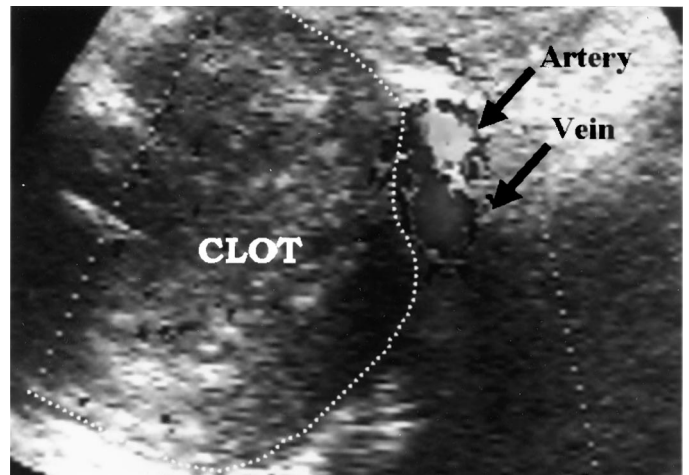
Color Doppler US image after injection of 5 mL (5000 U) of thrombin shows complete thrombosis of the pseudoaneurysm (*dotted line*). The right common iliac artery and vein are patent (*arrows*).
